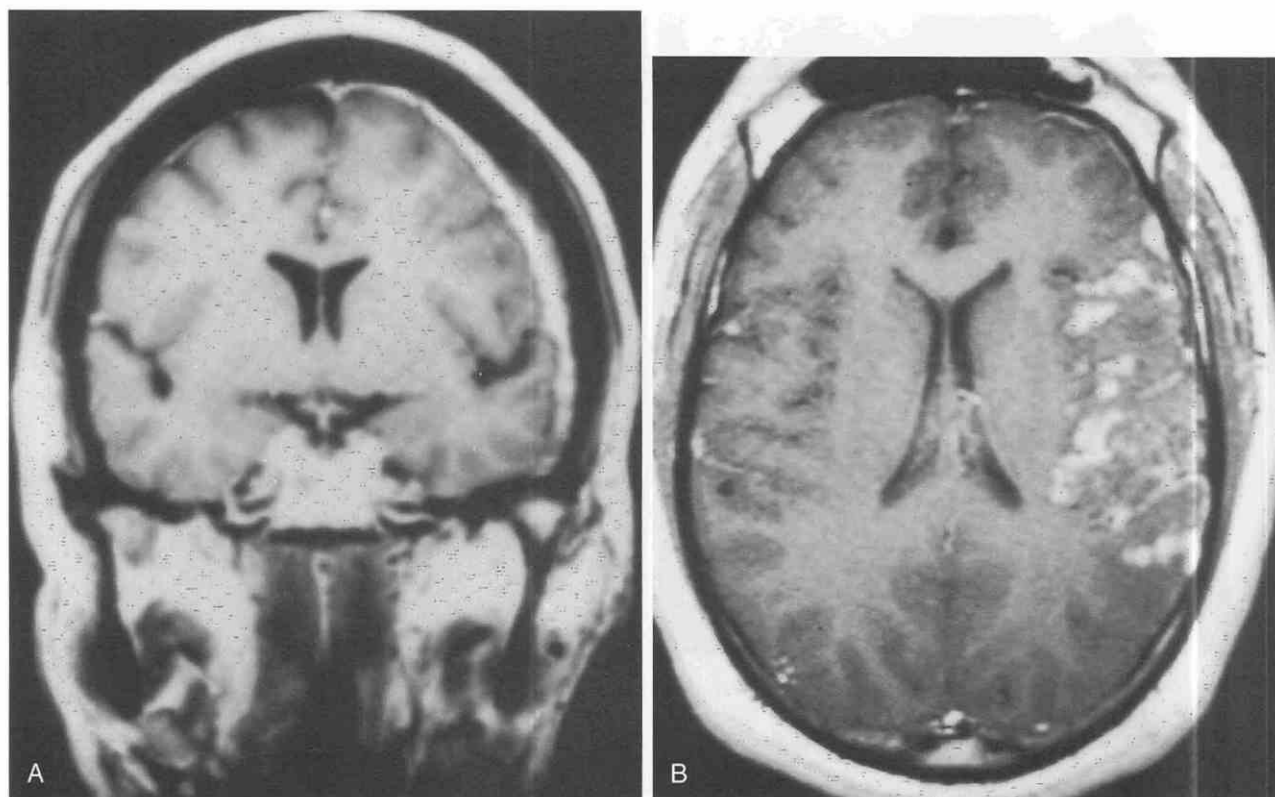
Non-neoplastic focal nodular and linear meningeal enhancement. A, Focal, linear enhancement in a dura/arachnoid pattern in sarcoidosis. (From Meltzer CC, Fukui MB, Kanal E, Smirniotopoulos JG: MR imaging of the meninges: Part I. Normal anatomic features and nonneoplastic disease. *Radiology* 201:297-308, 1996.) B, Focal, nodular enhancement in a pia/subarachnoid pattern mimics neoplasm in another case of sarcoidosis. (Courtesy of Robert L. Williams, M.D., University of Pittsburgh Medical Center, Pittsburgh, Pa.)
